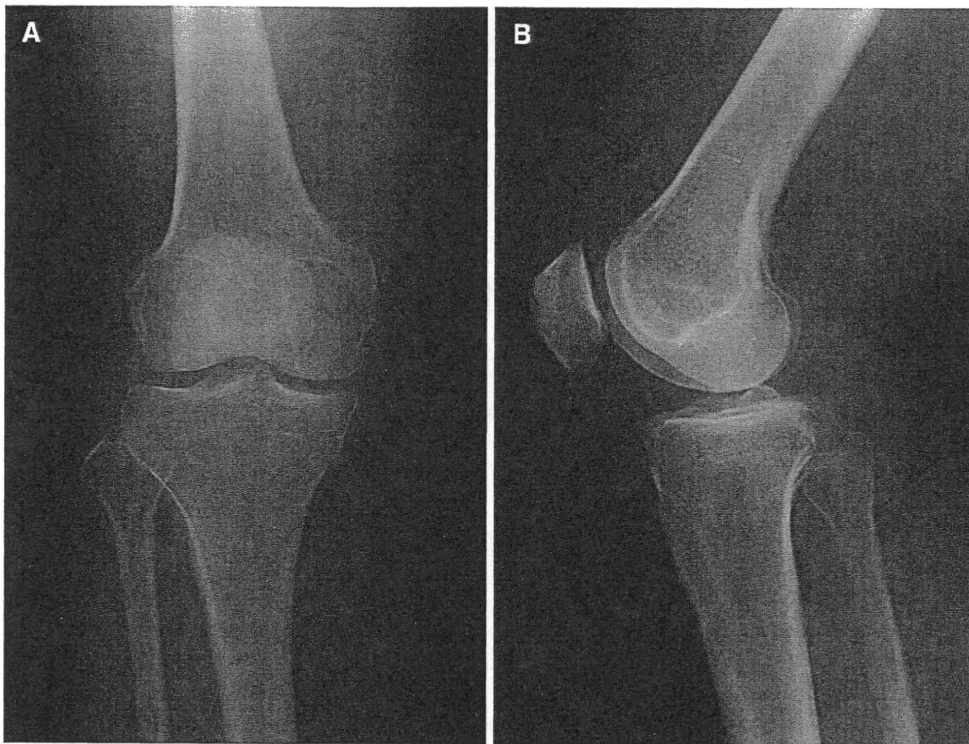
Preoperative anteroposterior (A) and lateral (B) plain radiography of the right knee joint shows slight narrowing of joint space and subchondral sclerosis with no osteophyte formation
